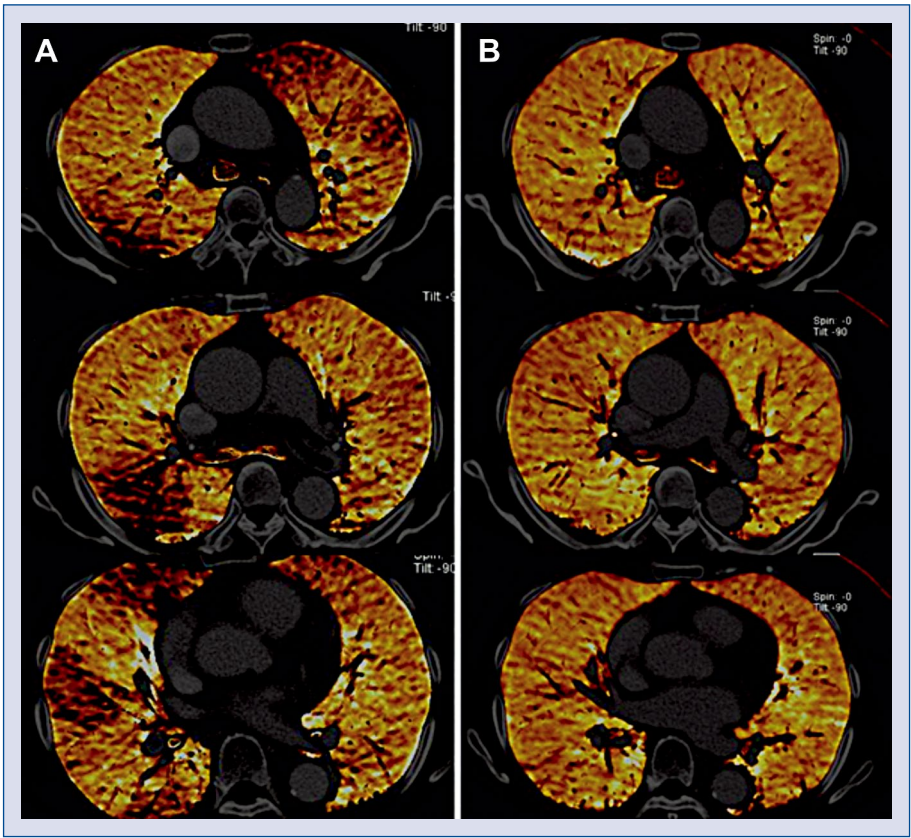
Dual energy computed tomography (DECT) in a 55-year-old female with acute pulmonary embolism. Pre-treatment DECT shows multi-focal hypoperfused regions (dark-brown color) corresponding to the location of vascular obstruction (A). Follow up DECT shows the disappearance of hypoperfused regions after 6-months of anticoagulation (B).
